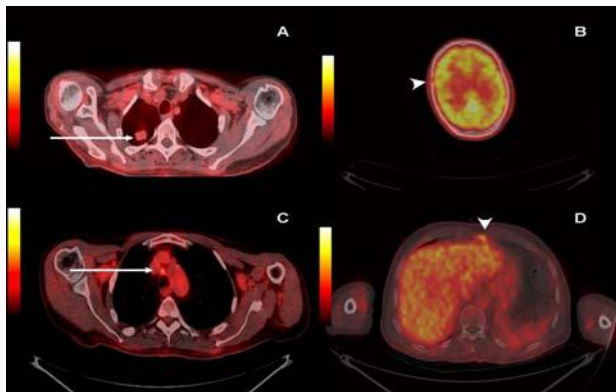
Transaxial FDG PET/CT images showing a mild ^{18}F -FDG uptake in an apical nodule of the upper right lobe (A, arrow), lytic bone metastasis on the right temporal bone and the sternum (B and D, arrowheads), and pretracheal lymph nodes (C, arrow).
